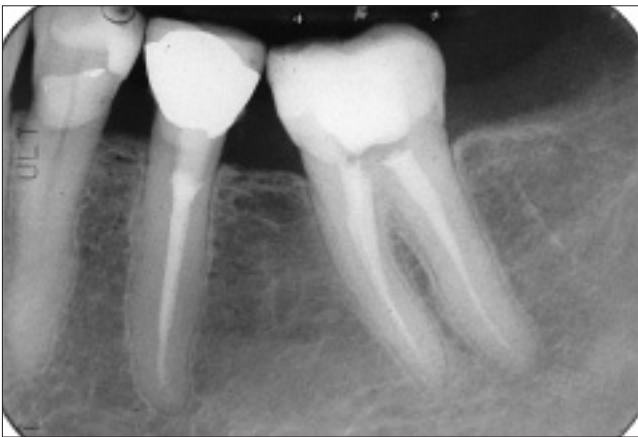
Postoperative radiograph of tooth 35 root canal re-treatment.
